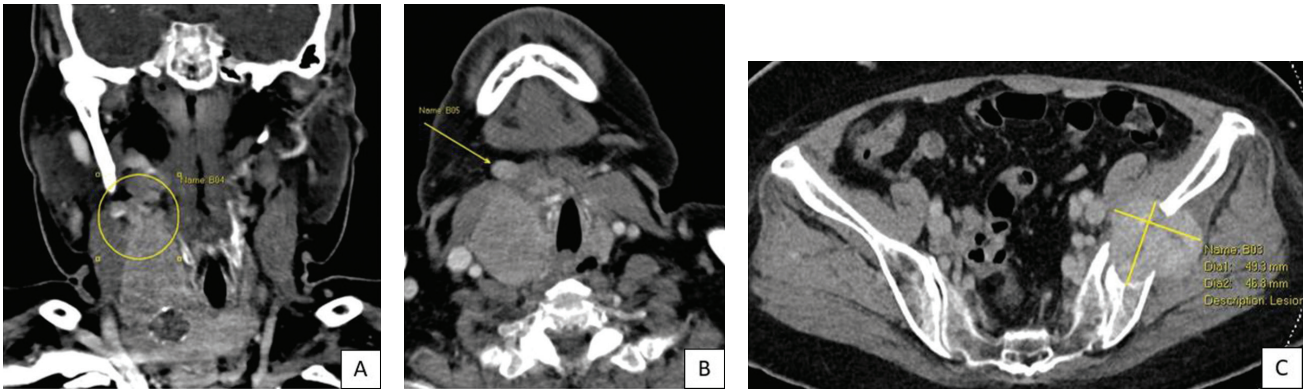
CT Neck (A) Coronal view showing extensive tumour thrombus inseparable from superior border of right thyroid lobe (yellow circle). (B) Axial view showing the abnormal right submental structure, either thrombosed anterior jugular vein or submental lymph node. (C) Destructive bony metastasis in left ilium.
